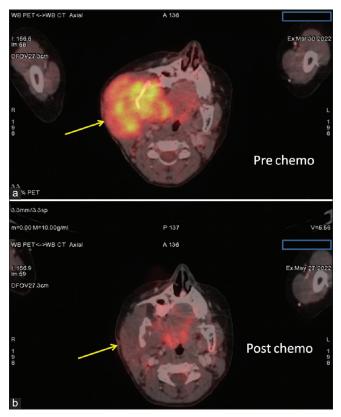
A 16-year-old male presented with paraparesis, (a) Positron emission tomography, computed tomography (PET-CT) image, shows increased fluorodeoxyglucose avidity in the paraspinal region (arrow on the right) at baseline. (b) PET-CT image shows complete metabolic response in the same region, post two cycles of chemotherapy (shown by arrow on the right).
